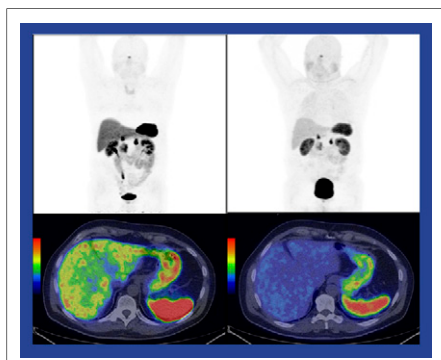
Restaging imaging in a patient with gastroenteropancreatic neuroendocrine tumors. Left: ^{68}Ga -DOTATOC PET at 1 h after injection. Middle and right: ^{44}Sc -DOTATOC PET/CT at 4 h after injection, with lower background activity and more conspicuous and numerous liver metastases. Optimal tumor-to-background ratio was achieved at 2–4 h after ^{44}Sc -DOTATOC injection.
